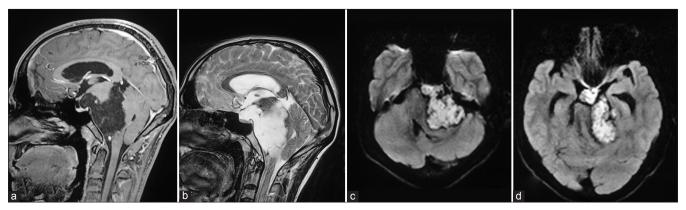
Preoperative magnetic resonance imaging of the brain revealed (a) T1 hypointense, (b) T2 hyperintense lesion in the left cerebellopontine angle cistern with (c and d) diffusion restriction and extensions into the ambient, quadrigeminal, and suprasellar cisterns with no postcontrast enhancement suggestive of epidermoid cyst.
